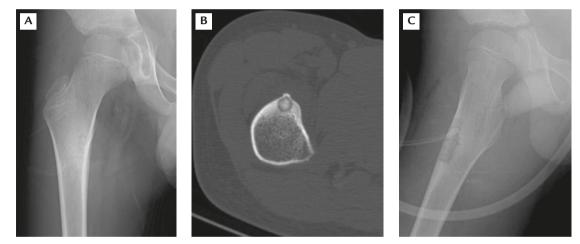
A 6-year-old boy with osteoid osteoma near the lesser trochanter: (A) radiograph; (B) computed tomography scan. (C) Radiograph soon after conventional open excision shows a bone defect measuring $3 \times 1 \times 1$ cm in the proximal femur.
